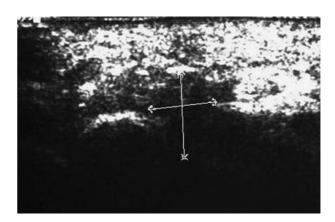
Intermetatarsal mass shown by ultrasonography
